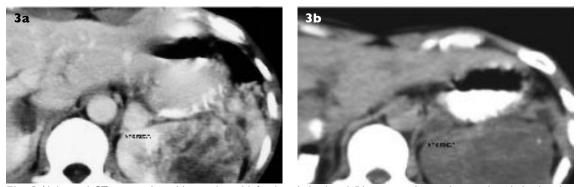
Abdominal CT images show (a) an enlarged left adrenal gland; and (b) one year later, a larger adrenal gland with a cystic component.
